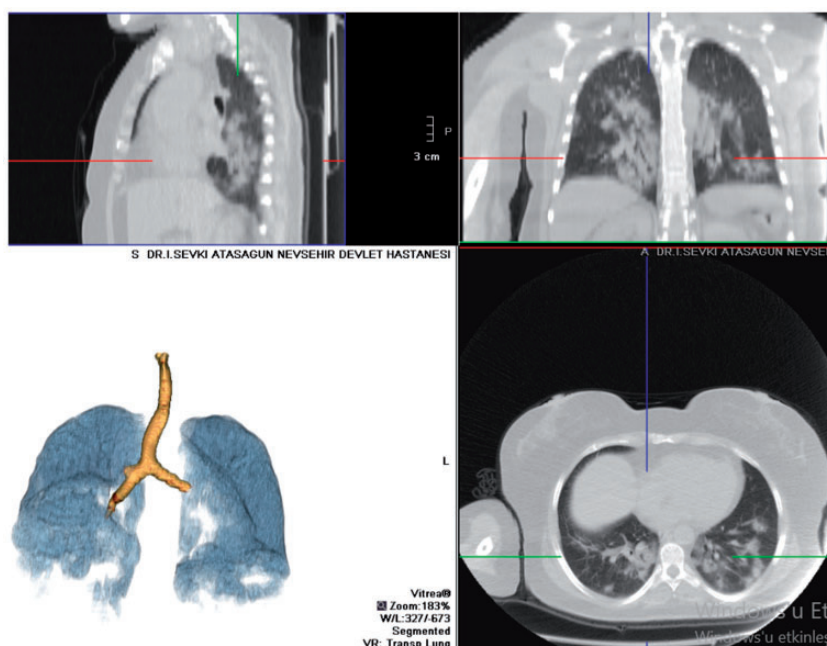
The MPR images of the patient in Figure 7 are observed in the three-dimensional CT pulmonary image created with the Toshiba Vitrea special program on the workstation. The affected areas of the lung are observed as defective areas. The defective areas are concentrated in the lower lobes of the lungs.
